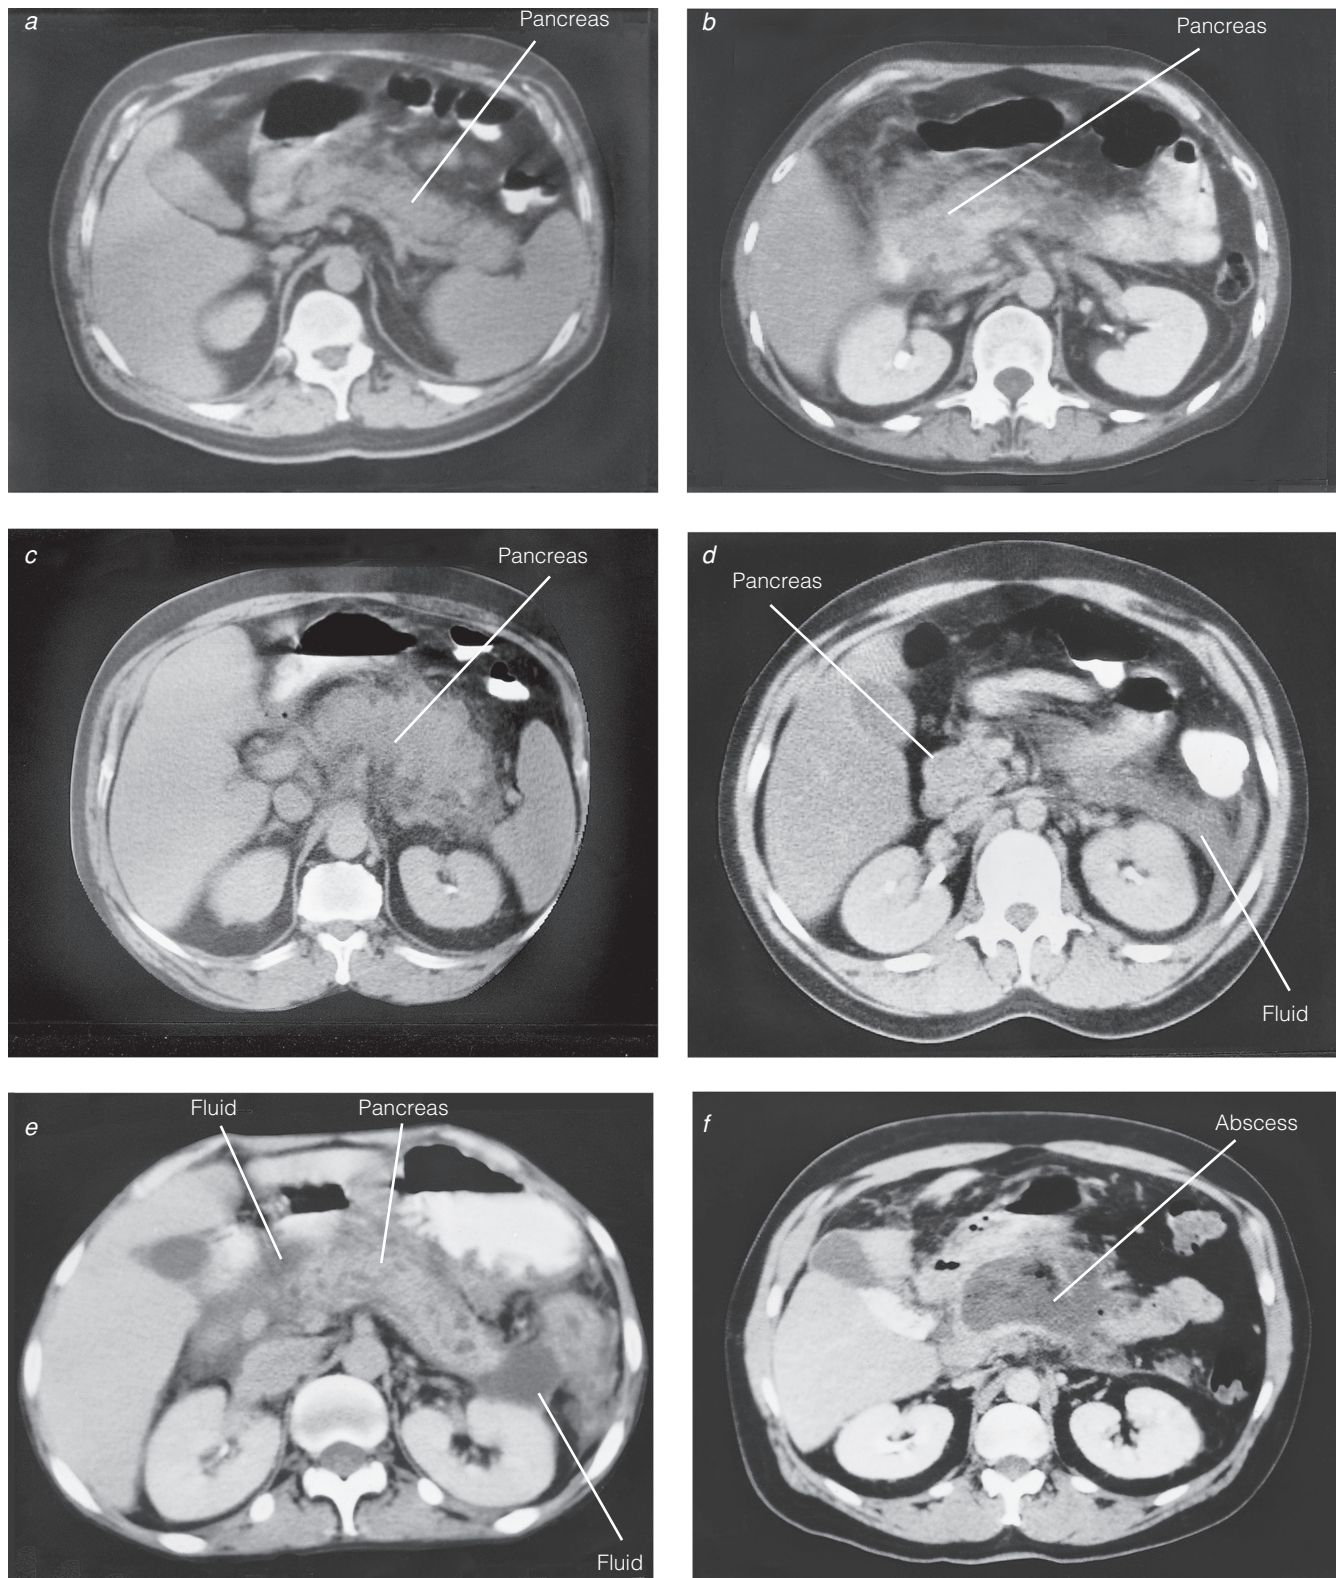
Pancreatic findings on a computed tomographic (CT) scan have been graded by Ranson into five categories: grade A, normal pancreas (a); grade B, diffuse enlargement of the pancreas and nonhomogeneous density of the gland (b); grade C, diffuse enlargement of the pancreas associated with peripancreatic inflammation (c); grade D, high-density fluid collection in the left anterior pararenal space (only the head of the pancreas is visualized at this level) (d); and grade E, diffuse enlargement of the pancreas with several intrapancreatic small fluid collections and poorly defined fluid collections adjacent to the tail and head of the pancreas (e). In the final CT scan (f), pancreatic abscess is demonstrated; partially encapsulated fluid collection containing bubbles of air represents a large abscess. Reproduced with permission from Berkman WA et al.¹¹⁵
